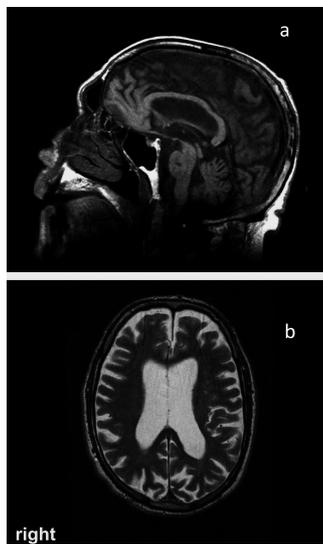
Brain magnetic resonance imaging of the patient. (A) Midsagittal T1-weighted magnetic resonance imaging demonstrating midbrain atrophy without significant pontine involvement, forming the silhouette of the “penguin” or “hummingbird” sign. A pontine white matter change due to a single old lacunar infarct is visible. Diffuse thinning of the corpus callosum. (B) Axial T2-weighted MRI showing frontal and parietal cortical atrophy and very mild evidence of deep white matter changes due to chronic ischemic lesions.
